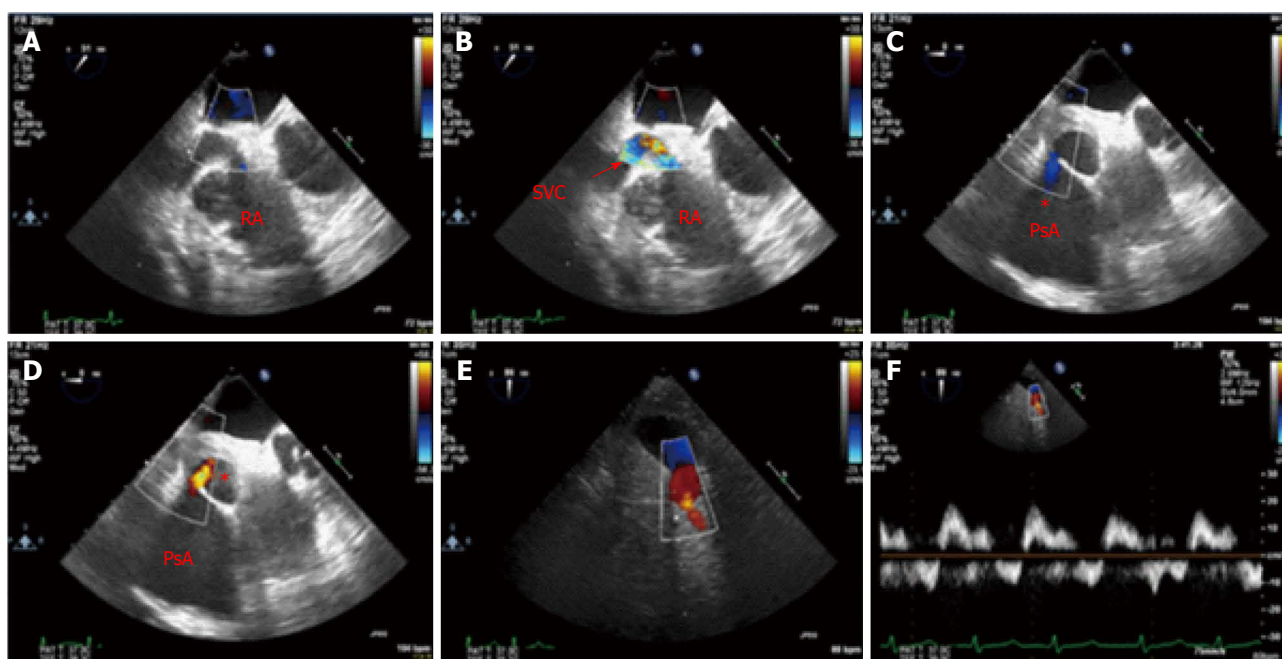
Intraoperative echocardiography showed superior vena cava compression by the giant pseudoaneurysm cranial lobe. A: Intraoperative transthoracic echocardiogram demonstrated normal left ventricular systolic function with left ventricular ejection fraction 60% and the giant pseudoaneurysm of SVG to RPDA in relation to the cardiac structures; B: Echocardiographic view of the pseudoaneurysm upper lobe compressing the superior vena cava (SVC); C, D: Blood flow by color Doppler of the SVC into the right atrium; E, F: Bidirectional flow is seen between the upper and lower pseudoaneurysm (PsA) lobes during diastole and systole respectively. Color Doppler and flow velocities of the giant pseudoaneurysm caudal lobe. RPDA: Right posterior descending artery.
